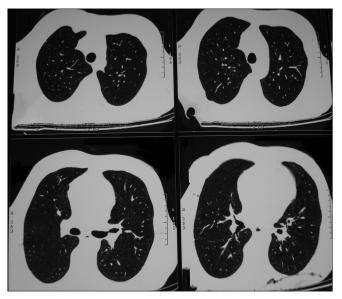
Chest CT scan showing the emphysematous changes
